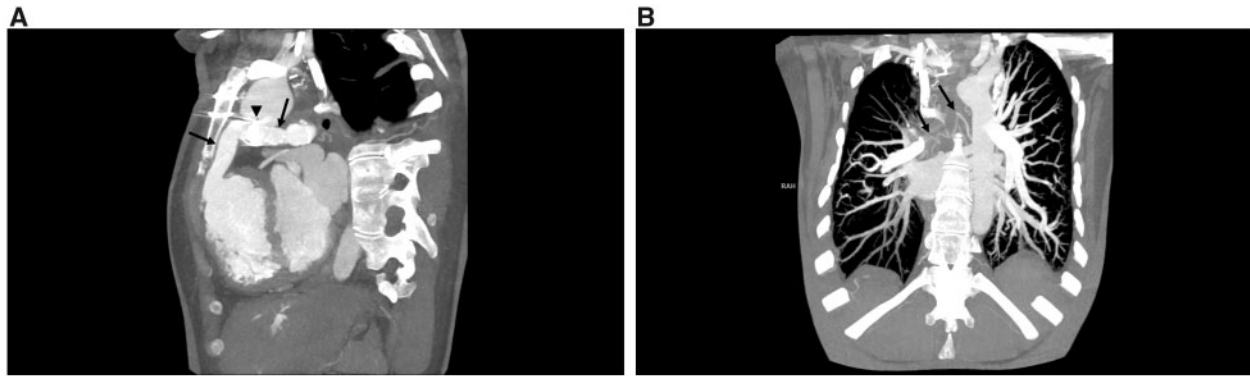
(A) Sagittal oblique maximum intensity projection image from a cardiac-gated computed tomography scan demonstrating the valved (arrowhead) right ventricle to pulmonary artery conduit (arrows). (B) Coronal oblique maximum intensity projection image from a cardiac-gated computed tomography scan. Small major aortopulmonary collateral artery (arrows) arising from the T6 level of the descending thoracic aorta coursing towards the right hilum.
